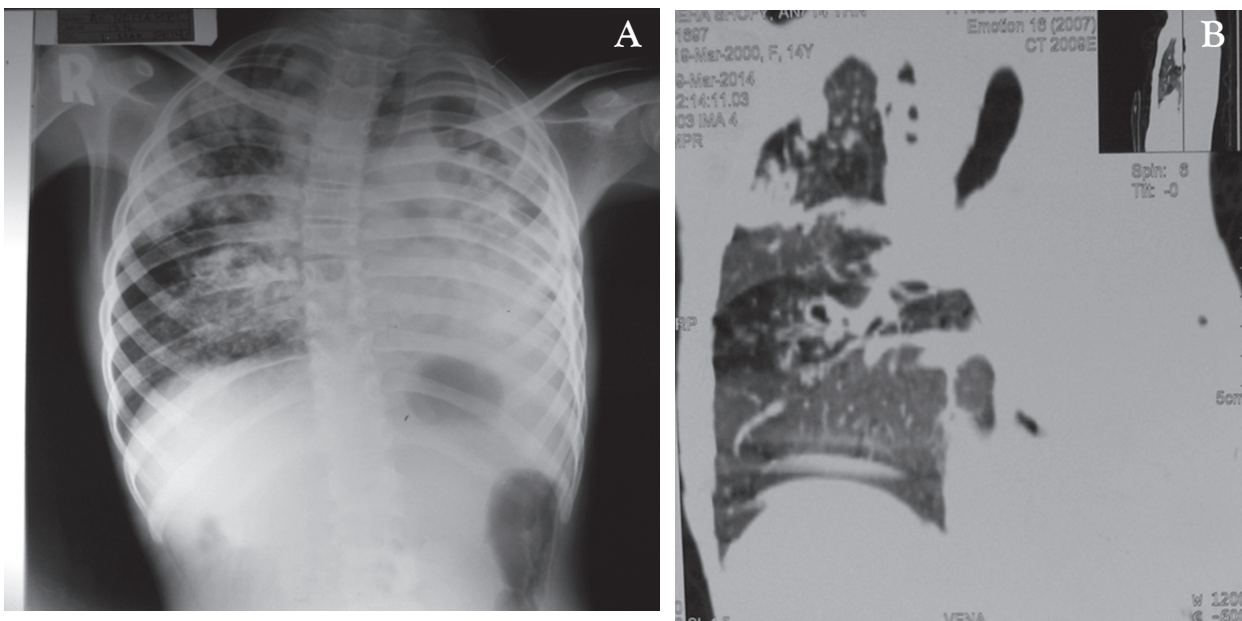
A. Patient chest X-rays on Emergency Department of Dr. Soetomo Hospital revealed the presence of infiltrate on right lung, tracheal deviation to the left, and left lung damage. B. MSCT scan also showed left lung damage.
